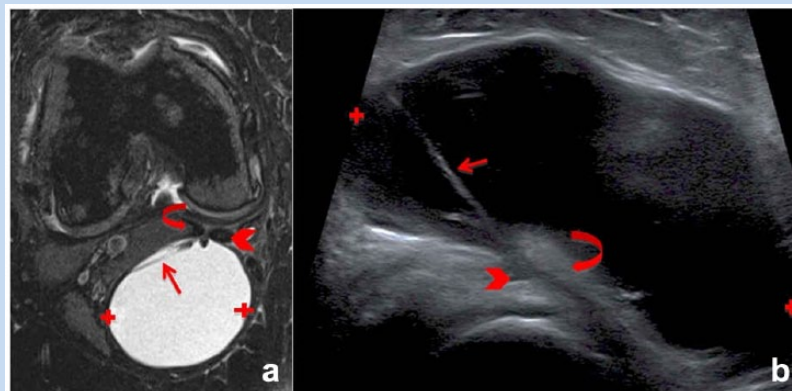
(a) Axial, proton density, fat-suppressed magnetic resonance image (MRI) and (b) axial ultrasound image of the same patient. Both images demonstrate a large mildly complex popliteal (Baker) cyst (calipers), with internal septations (arrows), extending posteriorly between the medial head of the gastrocnemius (curved arrow) and the semimembranosus tendon (chevron). Note: the patient was positioned (A) supine for MRI and (B) prone for ultrasound.
